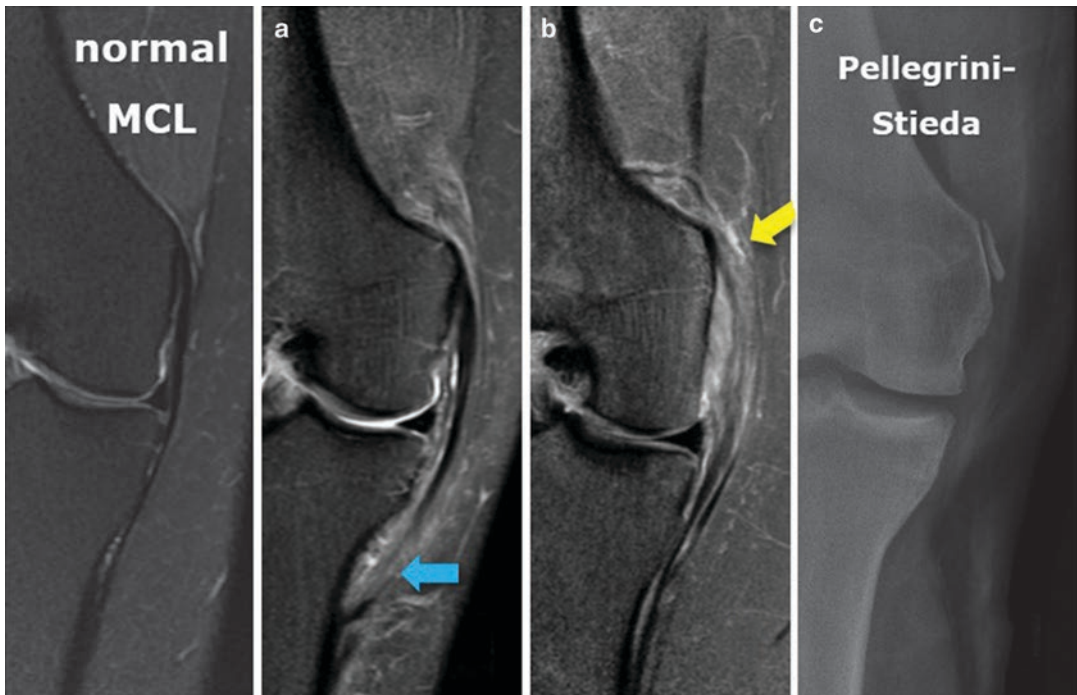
Coronal PD Fat Sat MRI of the right knee. (a) Distal tear of the MCL (blue arrow). (b) Proximal tear of the MCL (yellow arrow). (c) (X-ray): Pellegrini-Stieda
